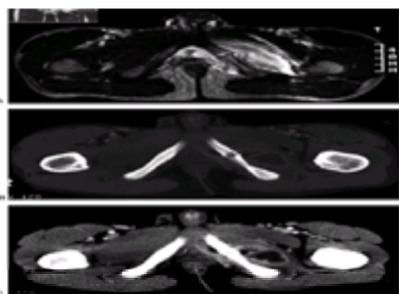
A: A T2 MR image of a 9-year-old boy with a history of increasing limp and hip pain for 1 week. The edema in the obturator muscle, the increased signal intensity around the ischiopubic synchondrosis, and the suggestion of abscess formation all suggest pelvic osteomyelitis. When the symptoms failed to resolve with intravenous antibiotics, CT-guided needle aspiration of the abscess was performed. B: Note the changes in the bone around the ischiopubic synchondrosis seen on the bone windows. C: Note the abscess seen on the soft tissue windows. Although MRI might still be the best choice for an initial imaging study in suspected pelvic osteomyelitis because of its ability to detect early changes within the bone, a great deal of information can be obtained from a good CT scan.
